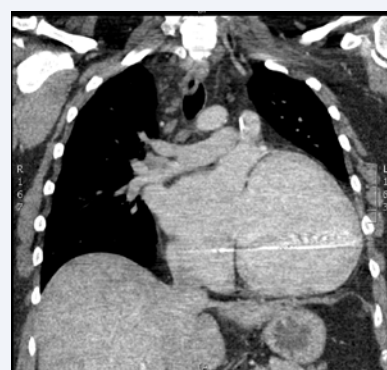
Preoperative CT scan showing persistent left-sided SVC with right SVC atresia.
